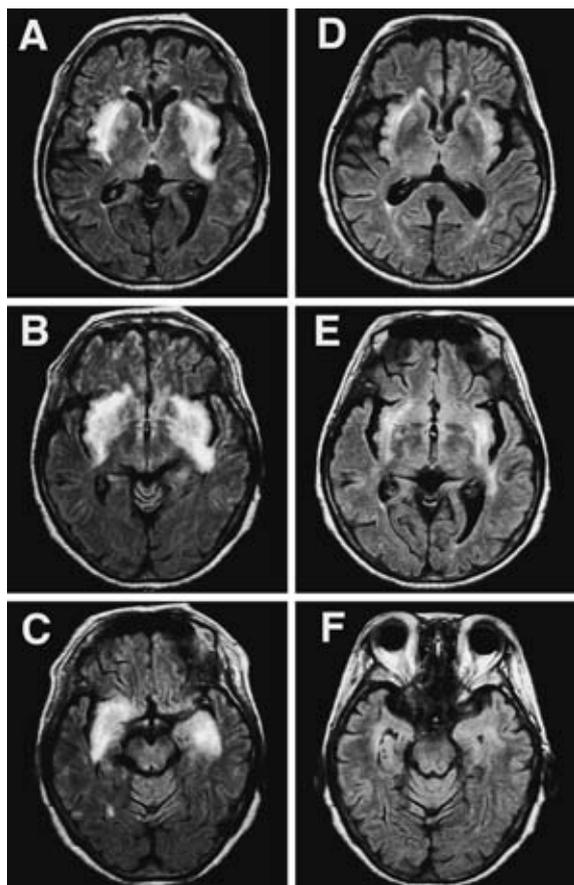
Fluid-attenuated inversion recovery MR images (TR/TE=10,000 msec/108 msec) obtained 4 days after admission (A, B, and C) and 25 days after admission (D, E, and F). High-intensity signal changes were seen in the medial temporal lobe, claustrum and insula cortex (A, B, and C). Twenty-five days after admission, these signal-intensity changes had markedly improved (D, E, and F).
